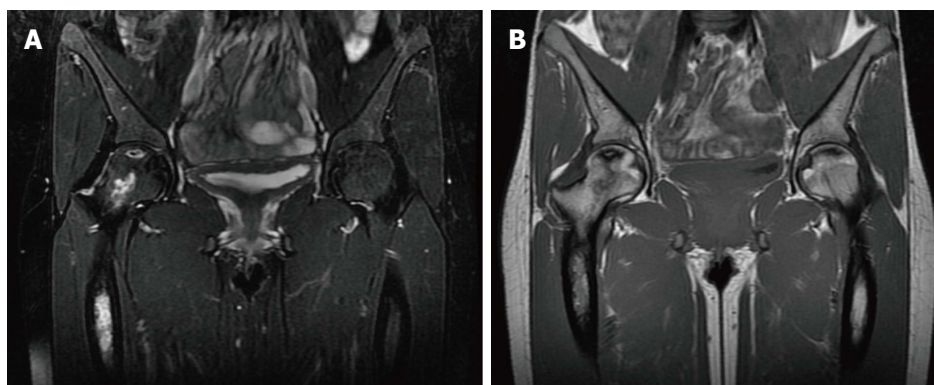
T2-weighted (A) and T1-weighted (B) coronal magnetic resonance imaging sequences demonstrating evidence of bilateral hip avascular necrosis and marrow changes consistent with sickle cell anemia.
